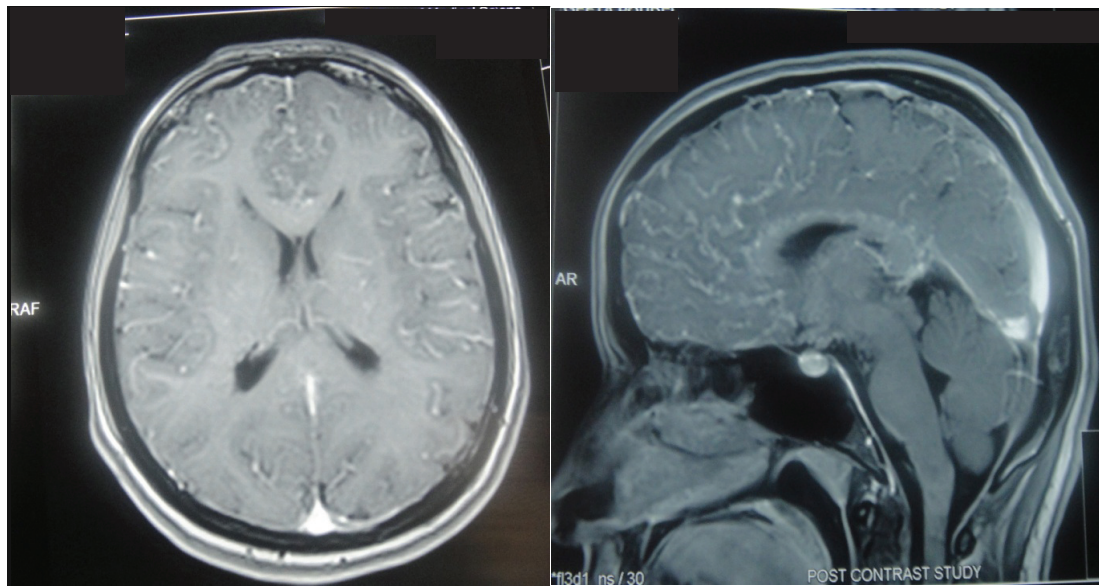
Post-contrast axial (A) and sagittal (B) T1-weighted images showing Gadolinium enhancement in a sulcal pattern due to the formation of collaterals from leptomeninges (“Ivy sign”).
